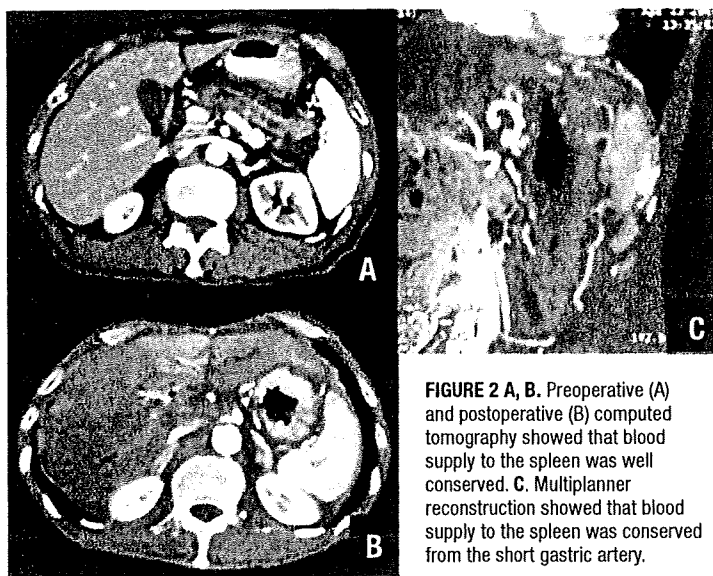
A, B. Preoperative (A) and postoperative (B) computed tomography showed that blood supply to the spleen was well conserved. C. Multiplanar reconstruction showed that blood supply to the spleen was conserved from the short gastric artery.
